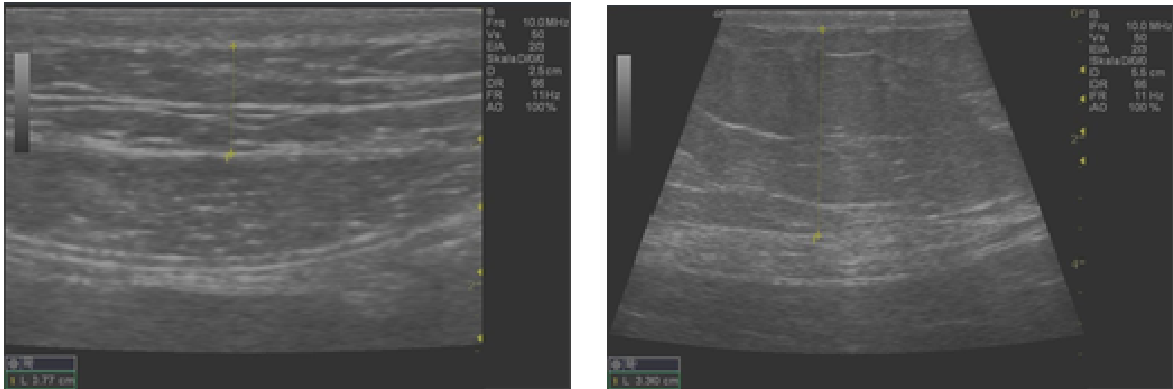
Ultrasound-picture of the subcutaneous adipose tissue: periumbilical and in the right subcostal region
